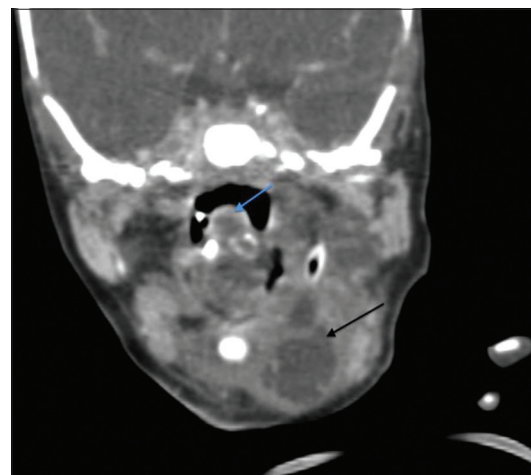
Coronal reformatted image of a post-contrast computed tomography showing mass in the oropharynx with calcification (blue arrow) and the residual cystic hygroma (black arrow) in the left side of the neck
